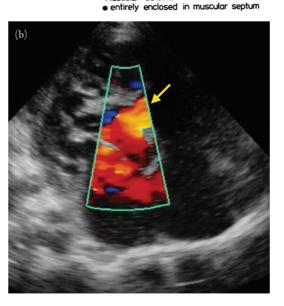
(a) Ventricular septal defect types. From Figure 2 of Sutherland G, Godman MJ, Smallhorn JF, Guiterras P, Anderson RH, Hunter S. Ventricular septal defects: 2D echocardiographic and morphological correlations. Br Heart J. 1982;47:316-328. (b) Ventricular septal defect on apical 4-chamber window. Color Doppler shows flow going right-to-left, suggestive of Eisenmenger syndrome.
